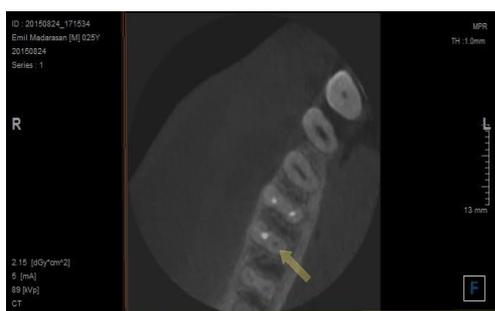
Lower left first molar referred for endodontic retreatment in which the CBCT scan a second canal could be identified in the distal root.
